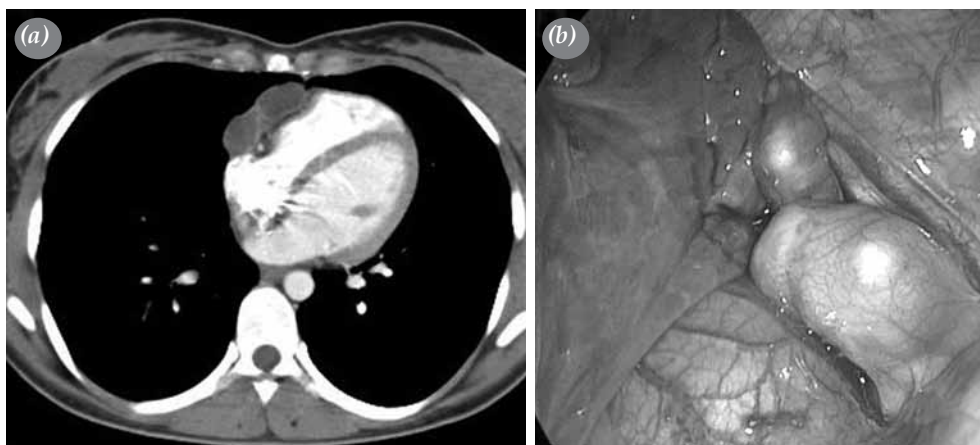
(a) Computed tomography scan shows two cysts located in paracardiac area and (b) their thoracoscopic images.
